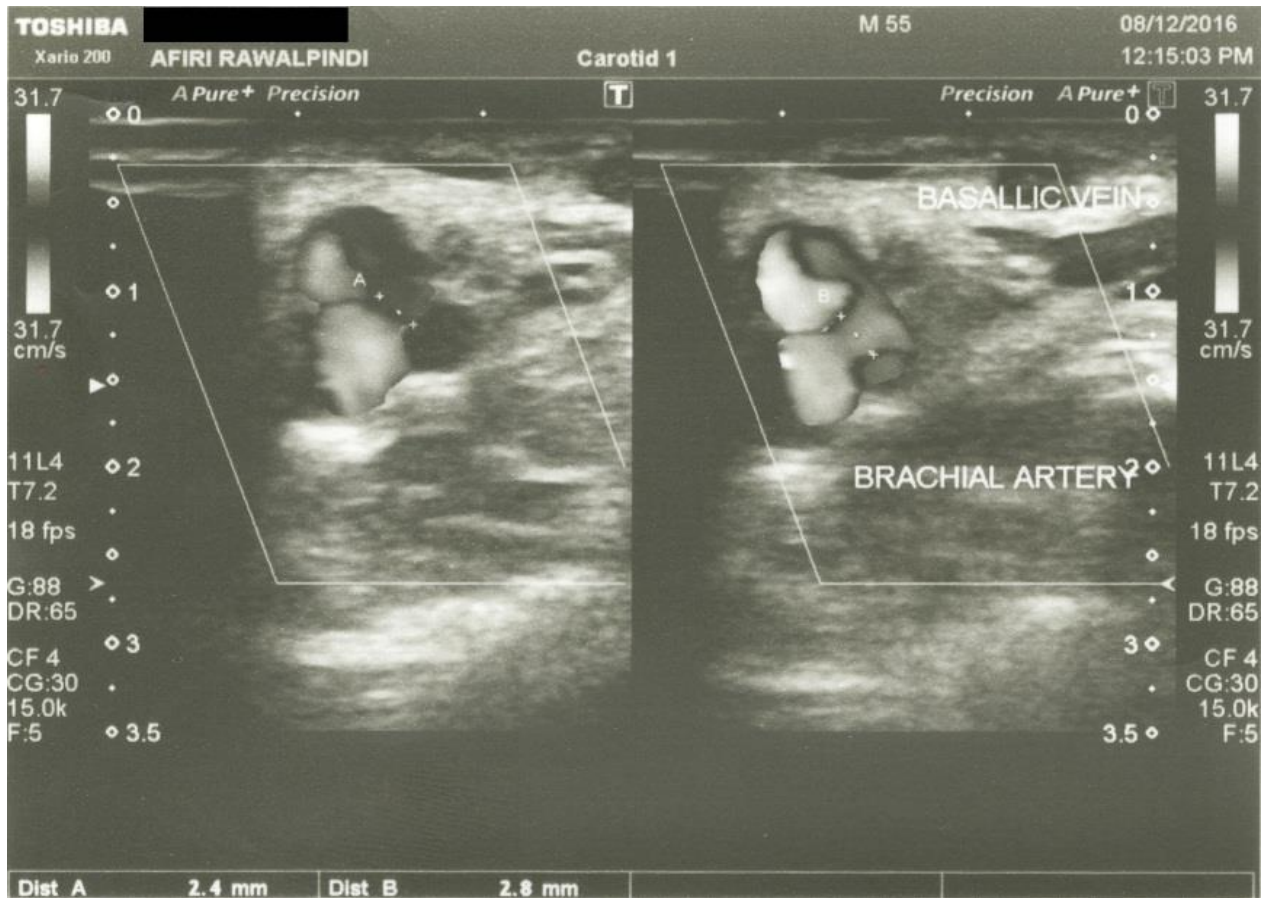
Doppler scan showing the fistula between the right brachial artery and basilic vein
